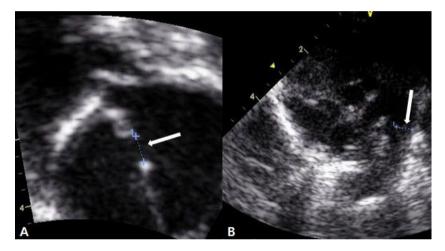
Transthoracic echocardiography shows arterial septal defect (A) and patent ductus artriosus (B).
